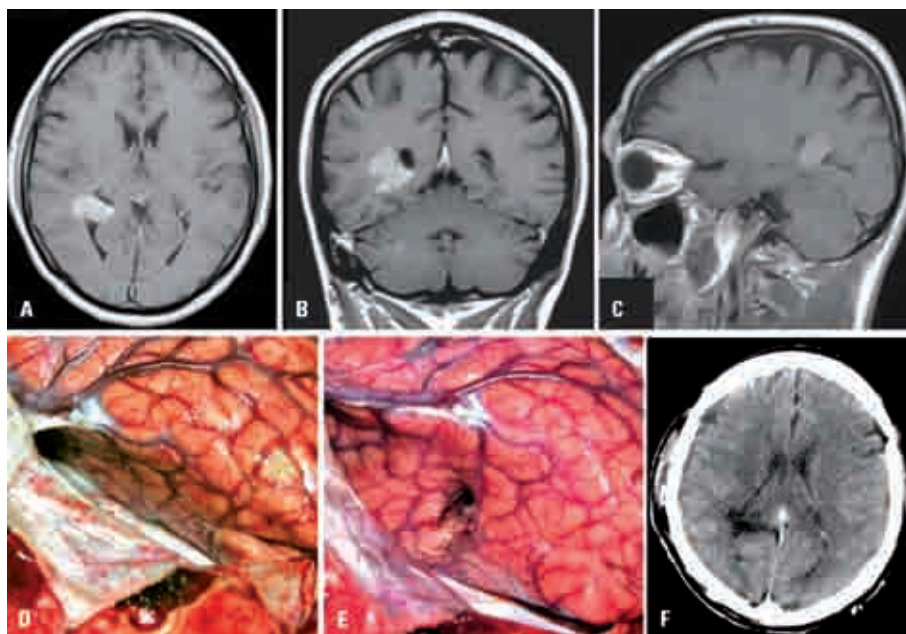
Case 6. A 47-year-old man with a five-year history of nonspecific syncope. [A, B and C] Preoperative contrasted MRI showed a small ($2 \times 1.5 \times 0.7$ cm) meningioma with irregular shape. [D and E] intraoperative photograph of interhemispheric parieto-occipital approach was performed through a small (1.5 cm) incision in the precranium. [F] Post-operative CT scan showed no residual tumor.
